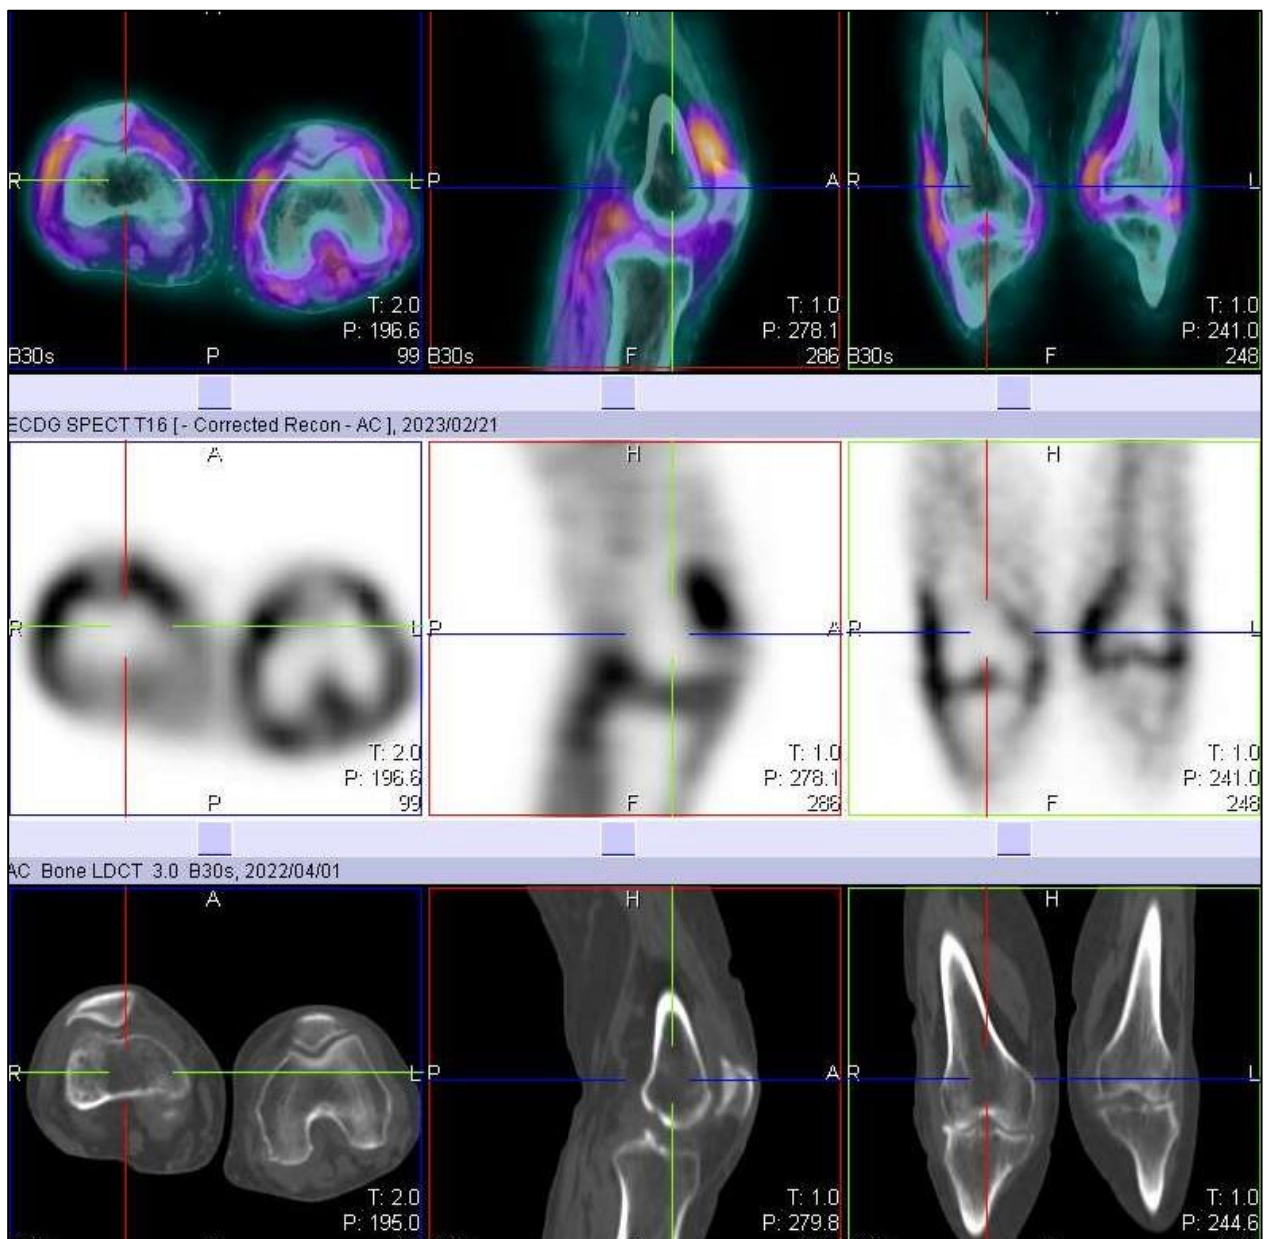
SPECT/CT, SPECT, and CT only images of an 82-year-old female with rheumatoid arthritis of both knees. Note the localization of radiotracer to the synovial space, without bone involvement.
